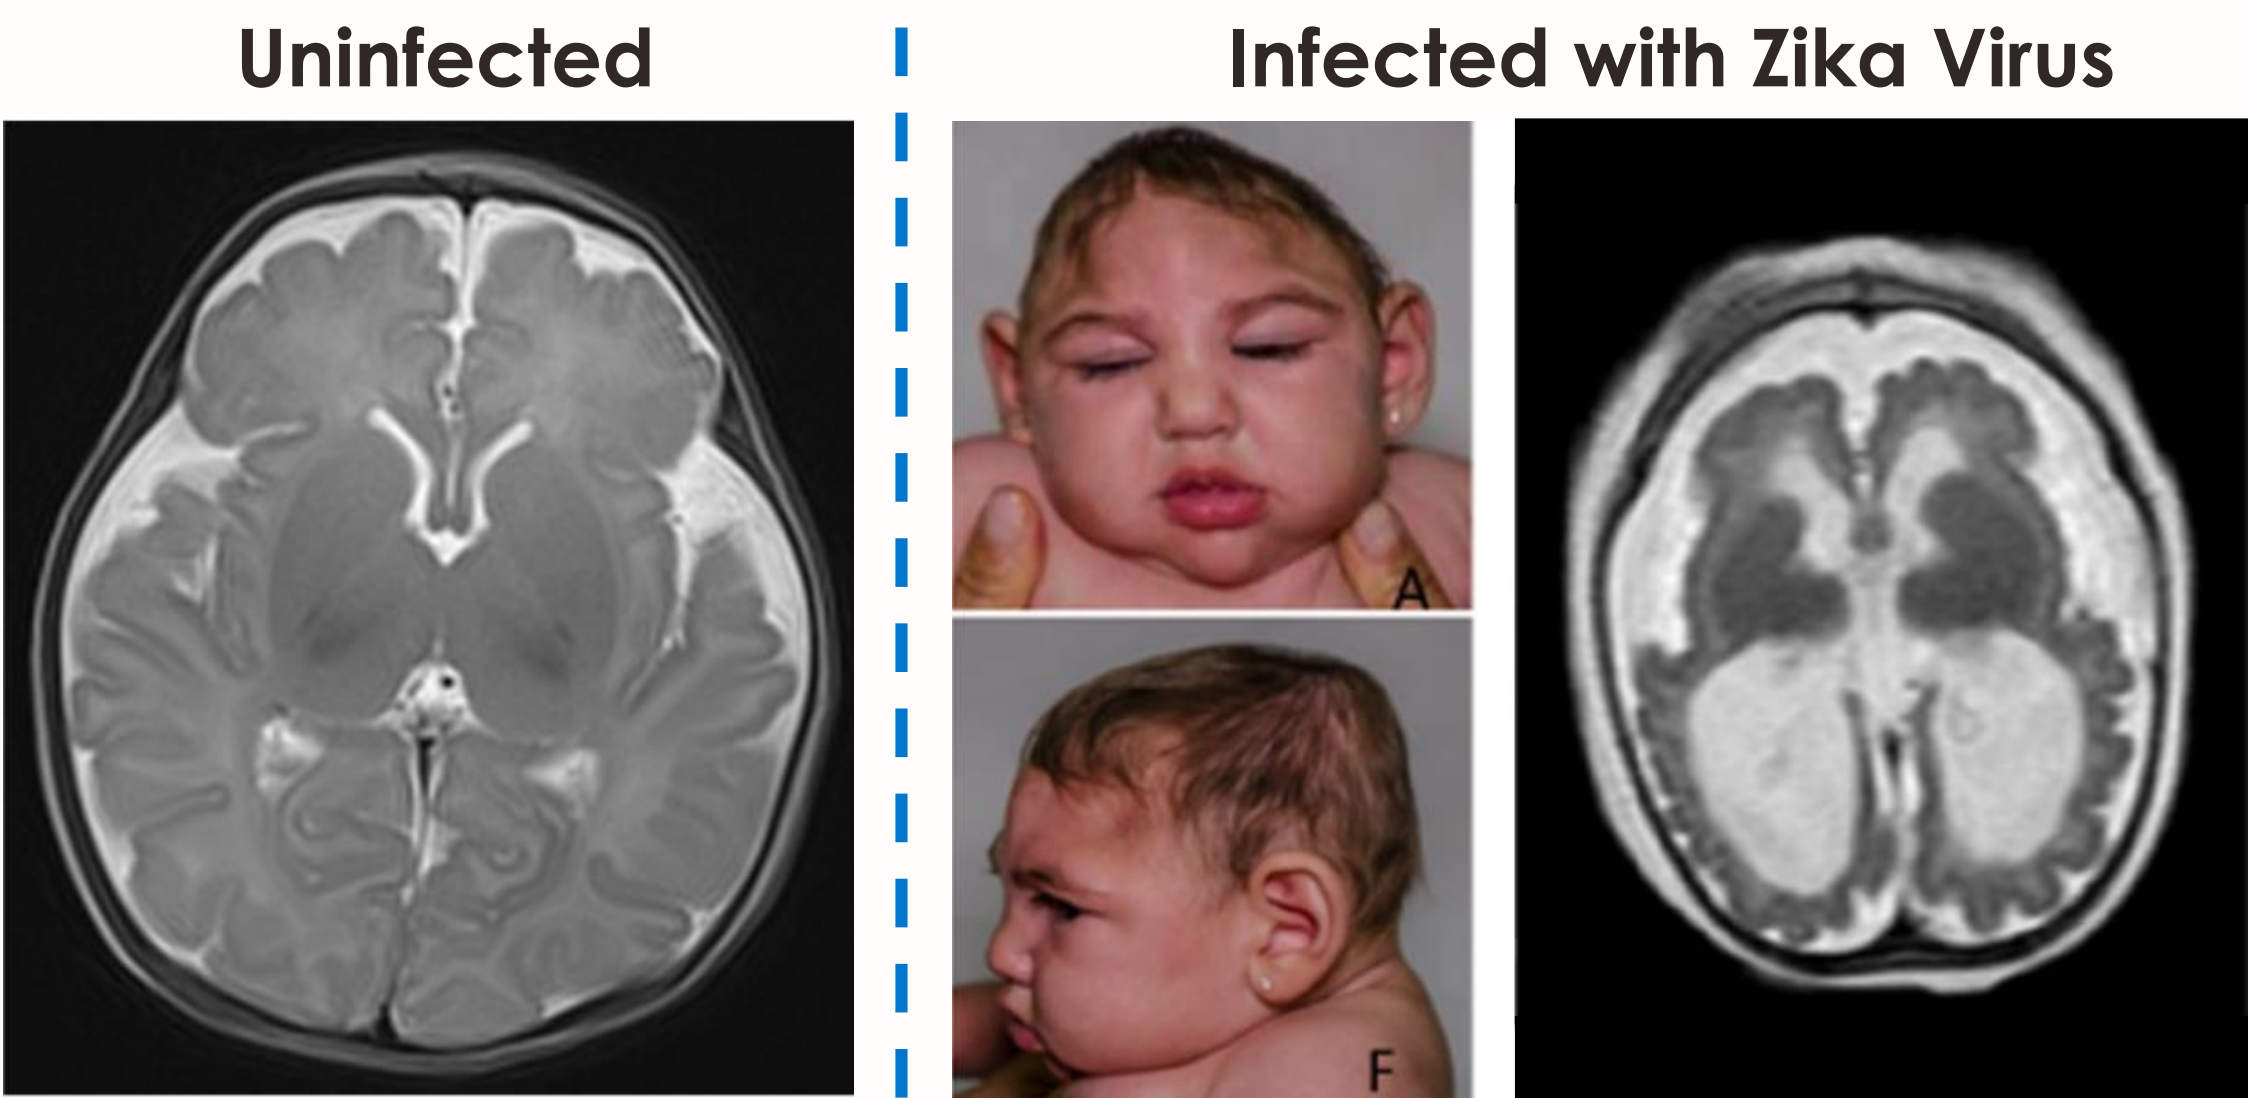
Virally induced brain injury. Prenatal viral infection can cause severe brain injury, as seen by visual examination (collapsed skull) and MRI (tissue loss, images not to scale).³
